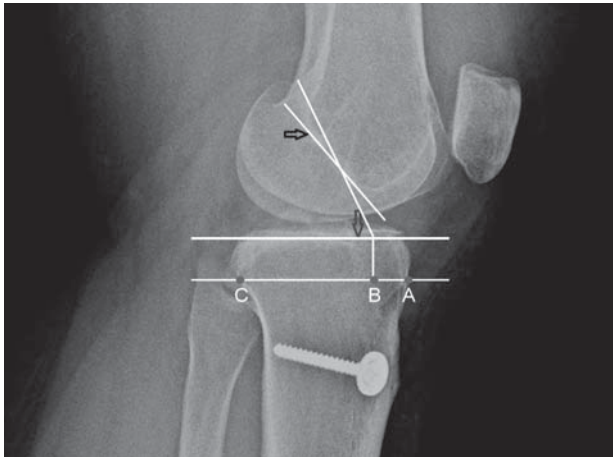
Lateral roentgenogram view of the patient's knee joint before revision. Tunnel placement was too anterior, as clearly defined by the sclerotic line and extra-cortex cortical screw retention. Black arrow shows the correct femoral tunnel position and blue arrow shows the correct tibial tunnel position. Blumensaat's line should correct 15 degree clockwise because of knee extension lag. AB/AC = roof-plateau intersection ratio.
